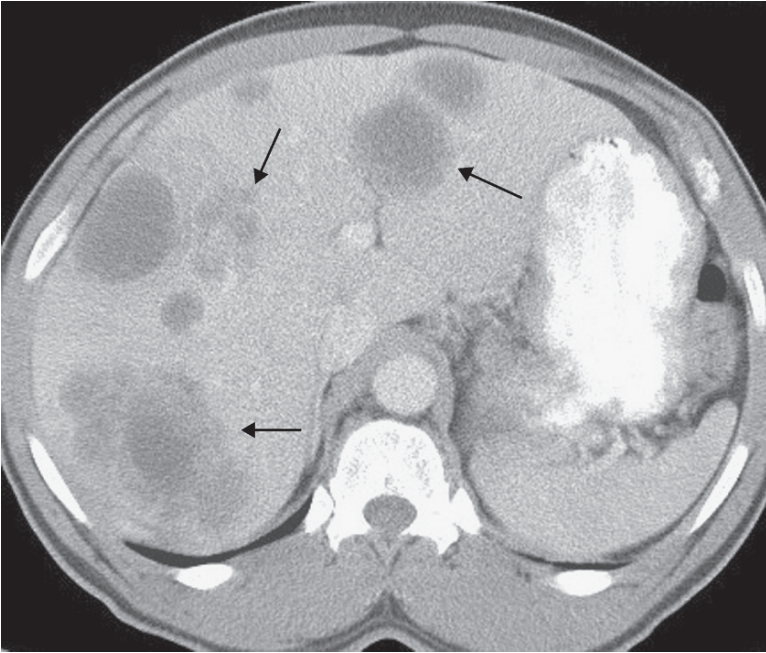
Axial contrast-enhanced CT image demonstrates multiple low attenuation, poorly circumscribed masses in the liver. Some lesions demonstrate central areas of necrosis
